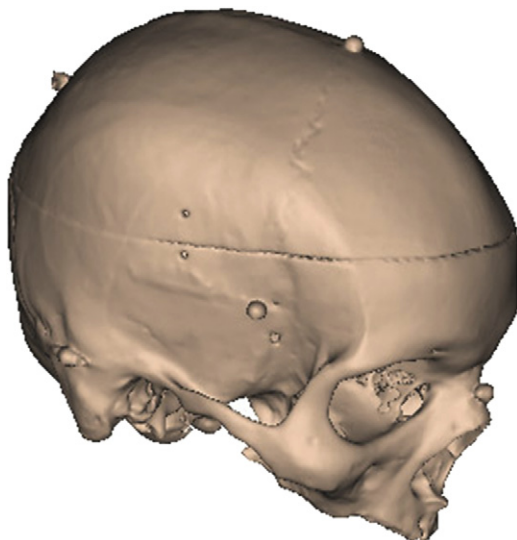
Reconstructed 3D model from CT scan.
